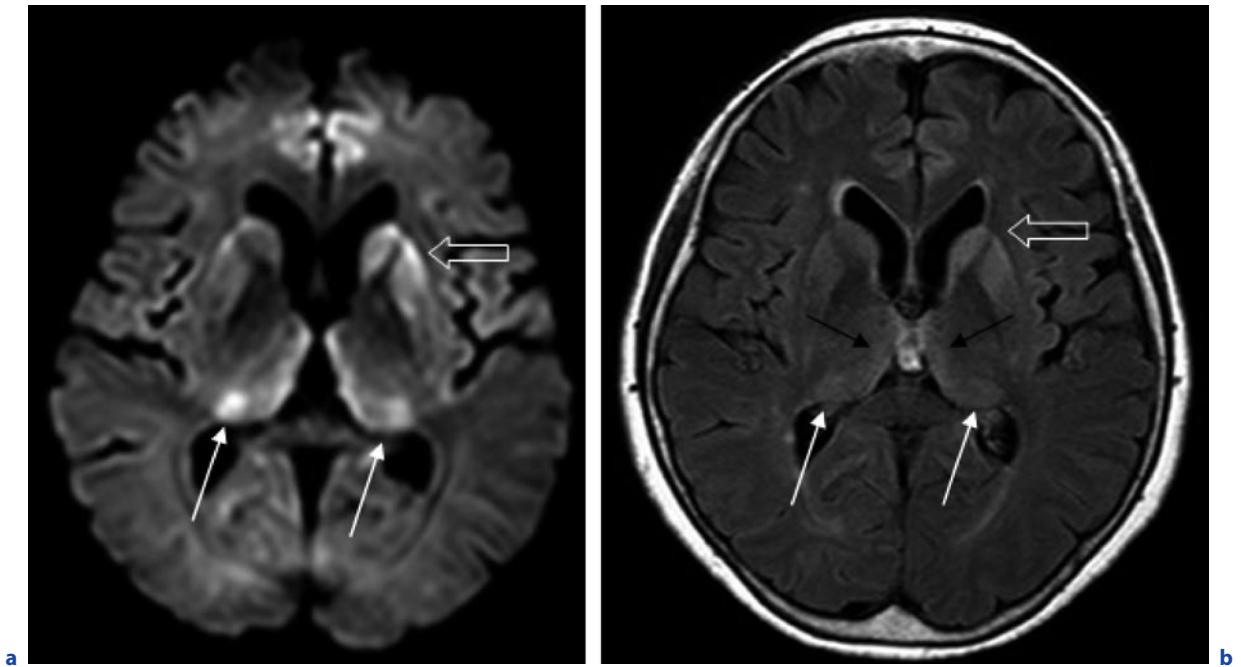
Sporadic Creutzfeldt-Jakob disease (sCJD). A 64-year-old woman with ataxia and cognitive decline for 3 months. a Axial DWI. b FLAIR image. Asymmetrically increased signal in the striate and thalami. Note the left caudate
